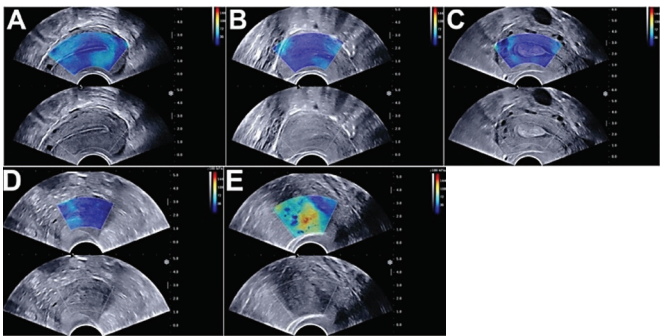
Transvaginal ultrasound with and without elastography: Ultrasound image of the endometrium (proliferative) in figure A, showing elastography a uniform blue area in the endometrium. (B) Ultrasound image of the secretory endometrium showing a uniform blue area in the endometrium. (C) Pathological findings confirmed an endometrial polyp in the uterine cavity. (D) Pathological results confirmed hyperplastic endometrium in blue. (E) The pathological findings confirmed an endometrial cancer in the uterine cavity. Elastography showed tumor lesions of a mixture of red, yellow and blue.<sup>18</sup>
